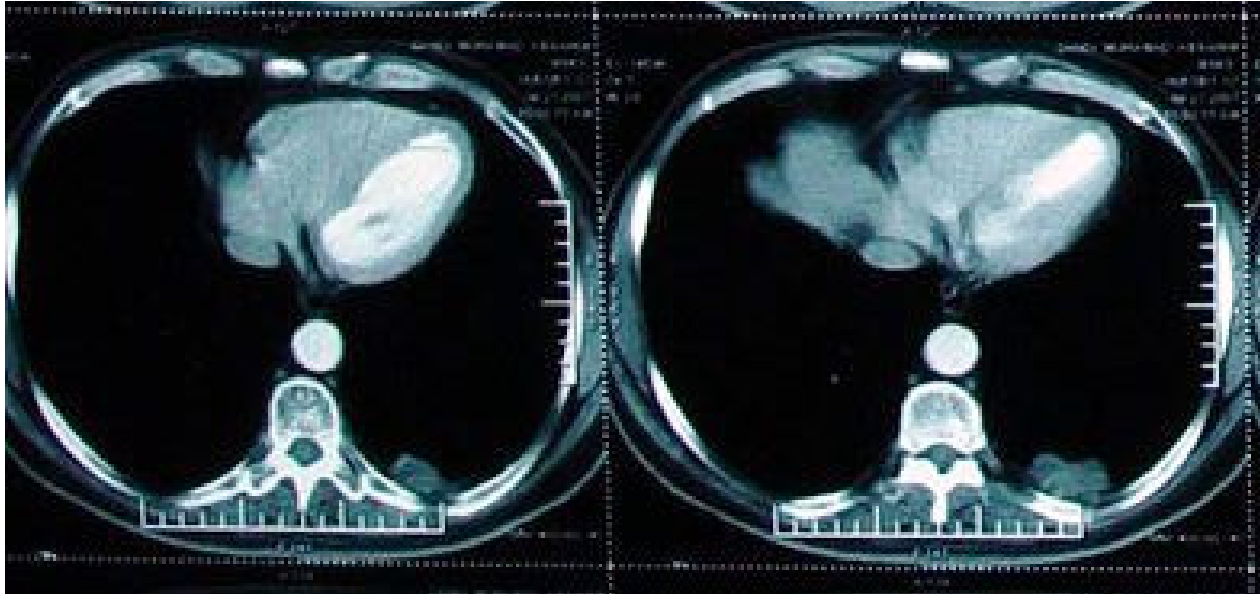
CT scan showing pulmonary metastasis
